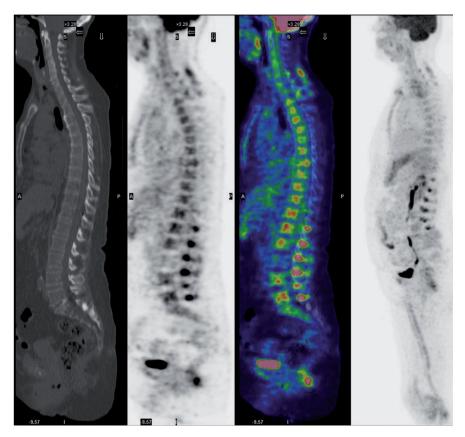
¹⁸FDG PET/CT: increased FDG uptake in the areas of the cervical and lumbar interspinous bursae, in the shoulders and in the trocanteric region consistent with bursitis as well as in the femoral and tibial arteries on both sides (grade 3 on a 0-3 scale) consistent with vasculitis.
